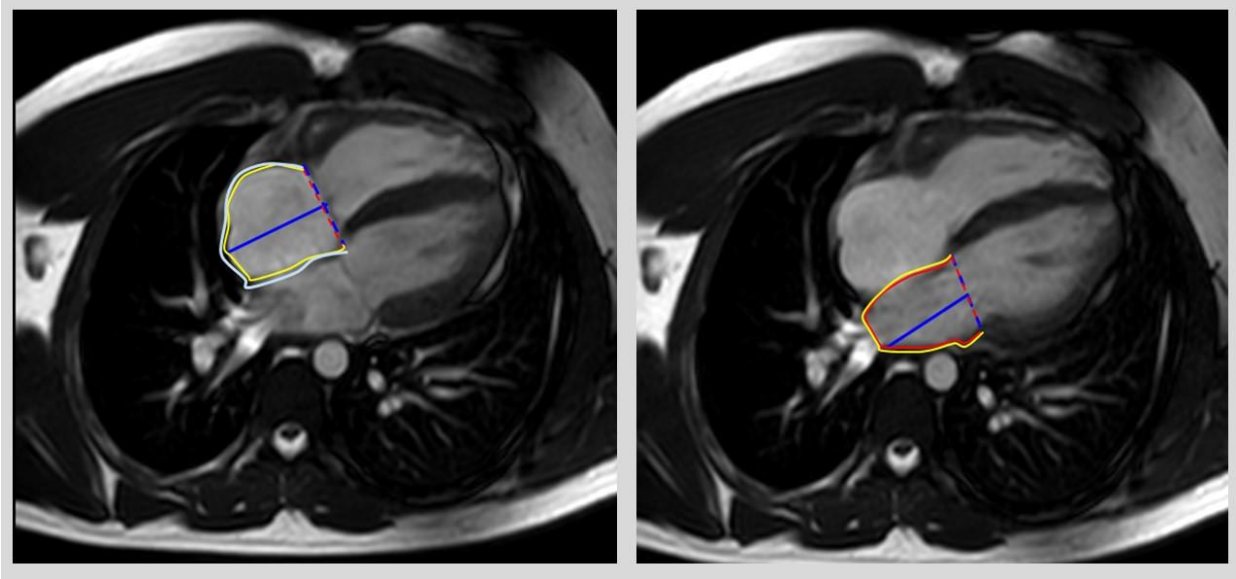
Representative feature-tracking strain cardiac MRI measurement technique for right (left) and left atria in four-chamber cine images
